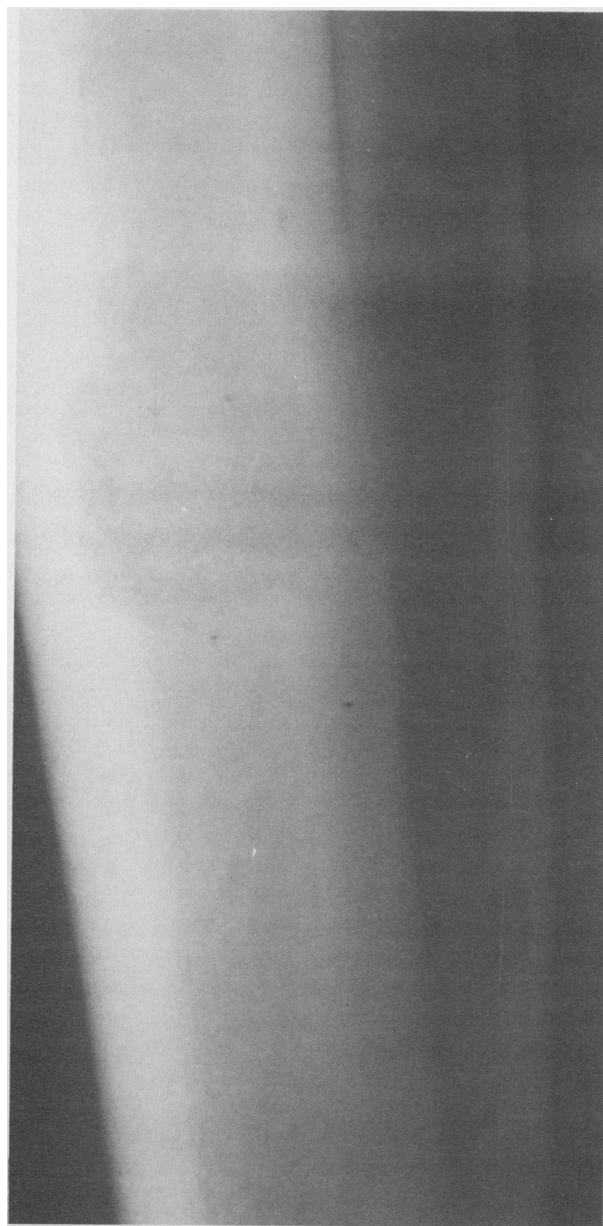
X-ray shows cystic and lytic lesions of tibia and fibula
